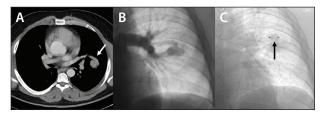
PAVM embolization. CT demonstrated a large PAVM (white arrow) (A). Angiography demonstrated a single feeding vessel (B) that was successfully embolized using a single 14-mm AVP (black arrow) (C).
